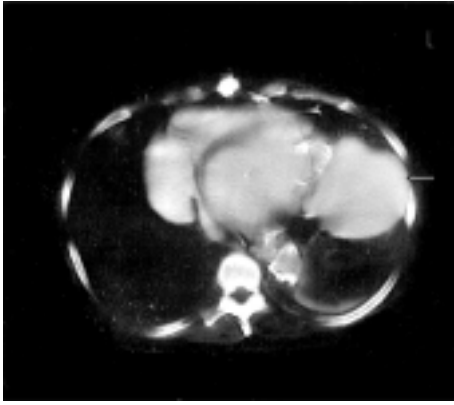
Chest computed tomographic scan with contrast shows a big spherical mass close to the left ventricle.
